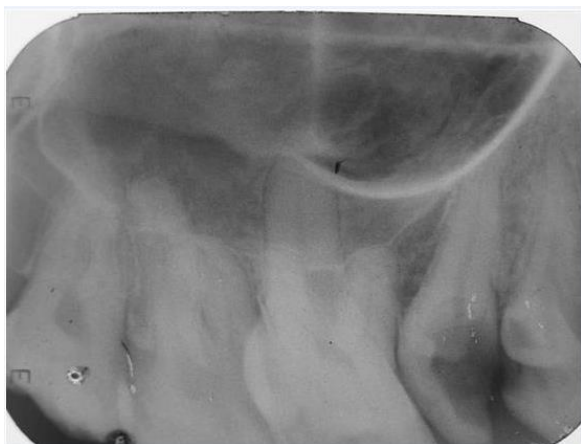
IOPAR showing periapical radiolucency with loss of lamina dura and root resorption of the premolars, first and second molars. The floor of the maxillary sinus was unable to appreciate
